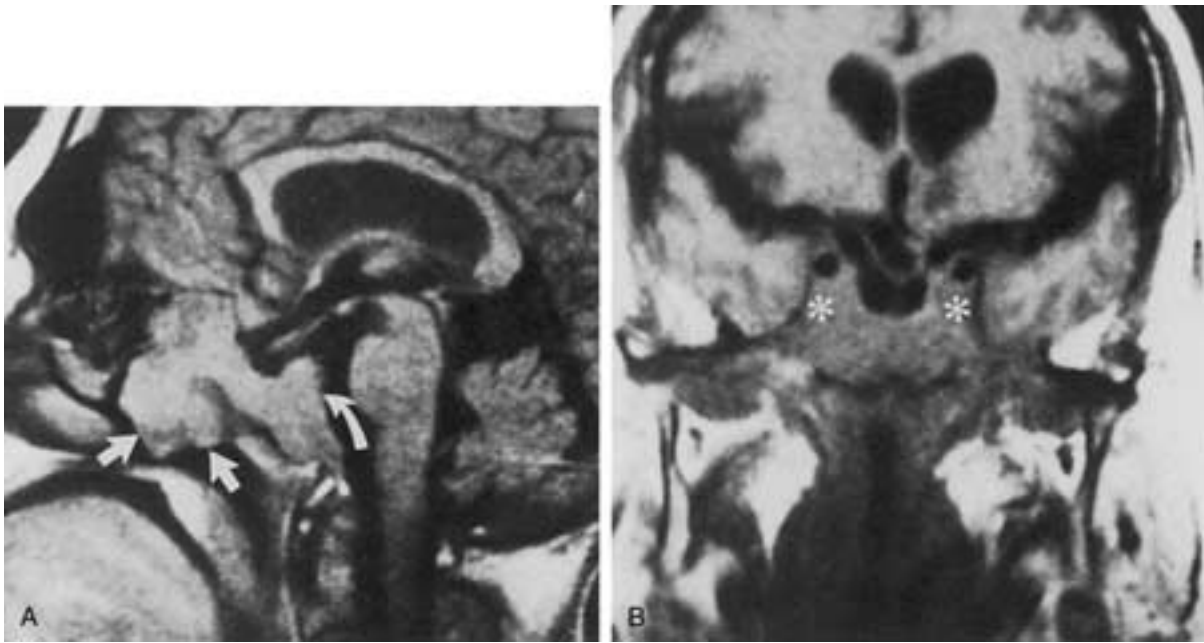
Intrasphenoid pituitary adenoma in a 38-year-old female presenting with amenorrhea, galactorrhea, and hyperprolactinemia. Midsagittal (A) and coronal (B) T1-weighted images show the presence of a mass involving the body of the sphenoid bone. The mass is relatively isointense to brain and extends inferiorly to the nasal fossa and nasopharynx (A, straight arrows), posteriorly to involve the clivus (A, curved arrow). It invades both cavernous sinuses (B, asterisk). A sphenoid sinus malignancy or chordoma also would be in the differential diagnosis.
